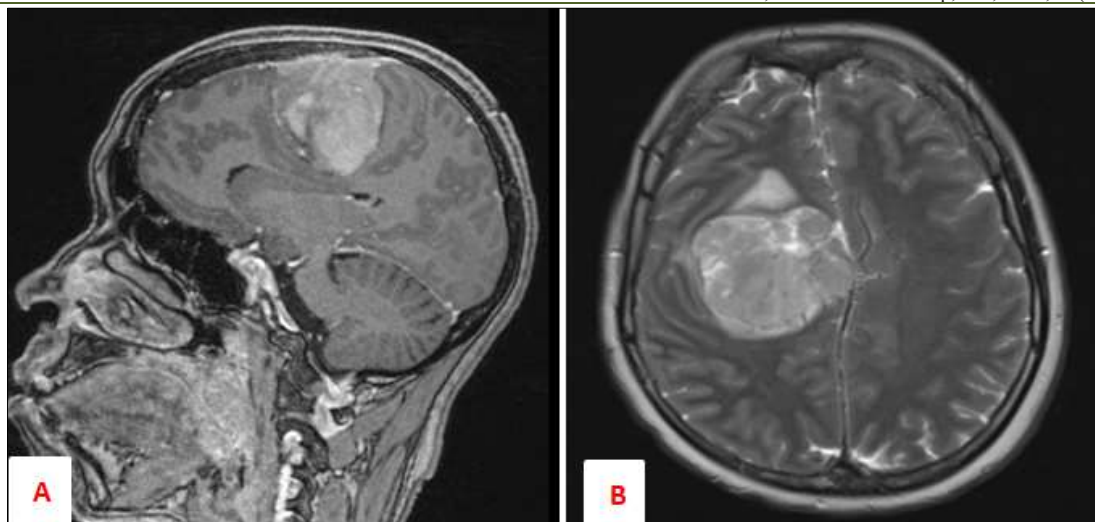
Sagittal T1 (A) fat-saturated MRI scans with Gadolinium injection and axial T2 (B) showing an extra-axial lesion with a broad base of implantation, exhibiting heterogeneous signal enhancement, strongly enhanced after injection with dural enhancement (dural tail), and exerting a mass effect on midline structures.
